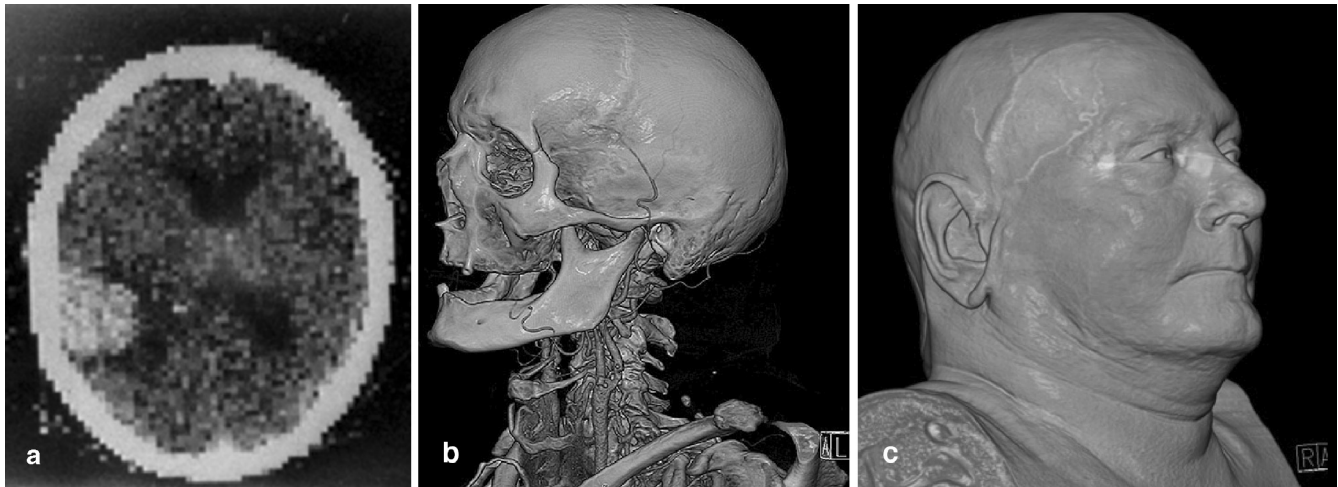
The evolution of CT over time is well documented by respective image examples. a The past: scanning of single anatomic slices, initially limited to the brain and to coarse matrices. b The present: fast scanning of volumes at high resolution enabling, for
